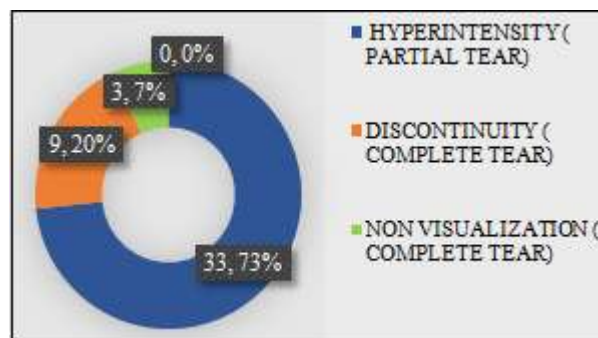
Pie depiction of observed MRI signs for ACL tears
